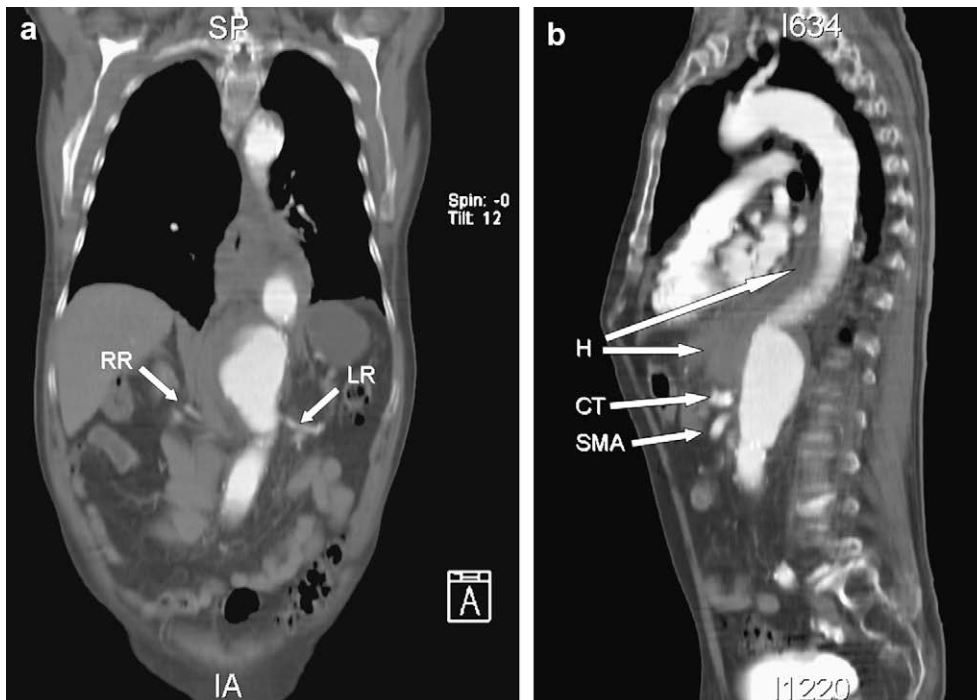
(a) Coronal reconstruction showing the aneurysm with the surrounding haematoma and the left renal (LR) and right renal (RR) artery. (b) Sagittal reconstruction showing the haematoma (H) and the coeliac trunk (CT) and superior mesenteric artery (SMA).
